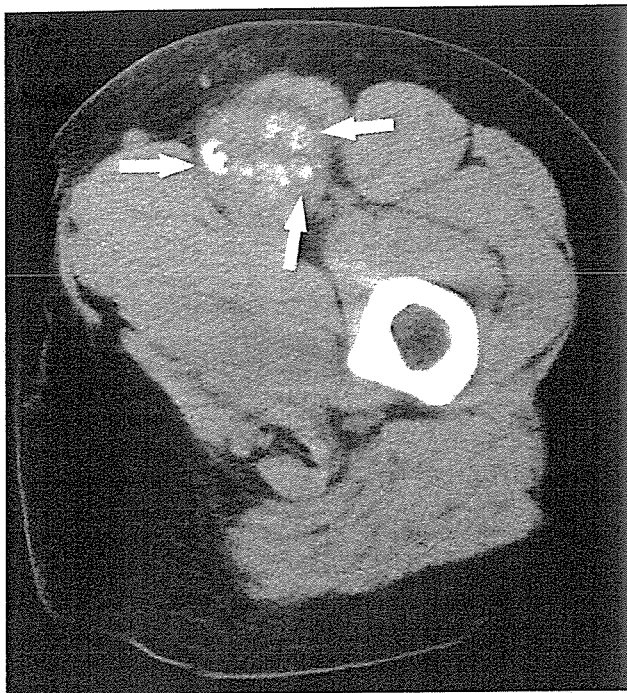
Unenhanced CT image obtained in a 14-year-old woman with synovial sarcoma (low-grade) of left groin. Image obtained at the level of inguinal region shows round or punctate calcifications (arrows) within the tumor.
